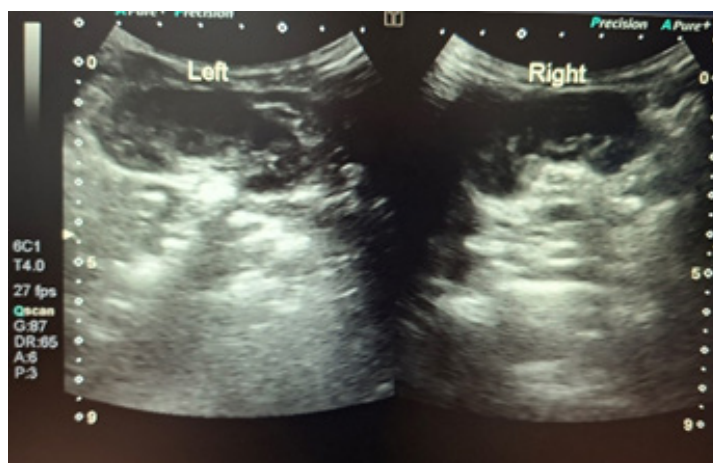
Ultrasound examination of the kidneys: a) ectasia of the renal pelvis of the right kidney
